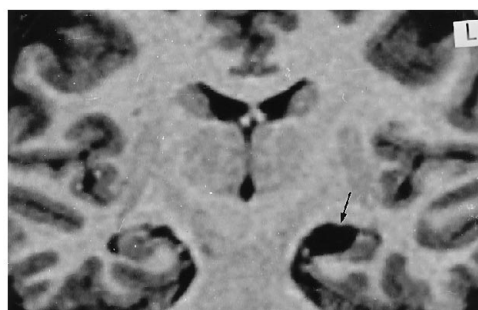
Patient 9: abnormal hippocampal formation associated with a cyst. A, Oblique coronal T1-weighted section. The cyst was present in the left choroidal fissure and the perimesencephalic cistern (arrow). The hippocampal formation was reduced to a small crescent; the hippocampal fissure was broadly opened; and its normal folding, which brings the dentate gyrus in contact to the subiculum, was not complete.
